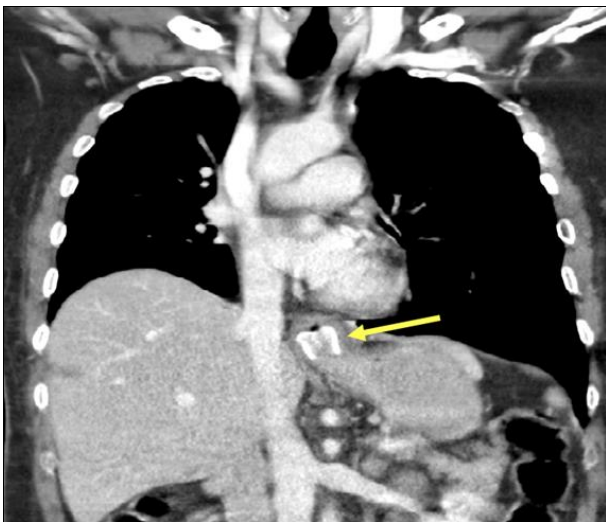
Contrasted CT thorax in coronal reformatted view. Yellow arrow showing impacted chicken bone at gastroesophageal junction
